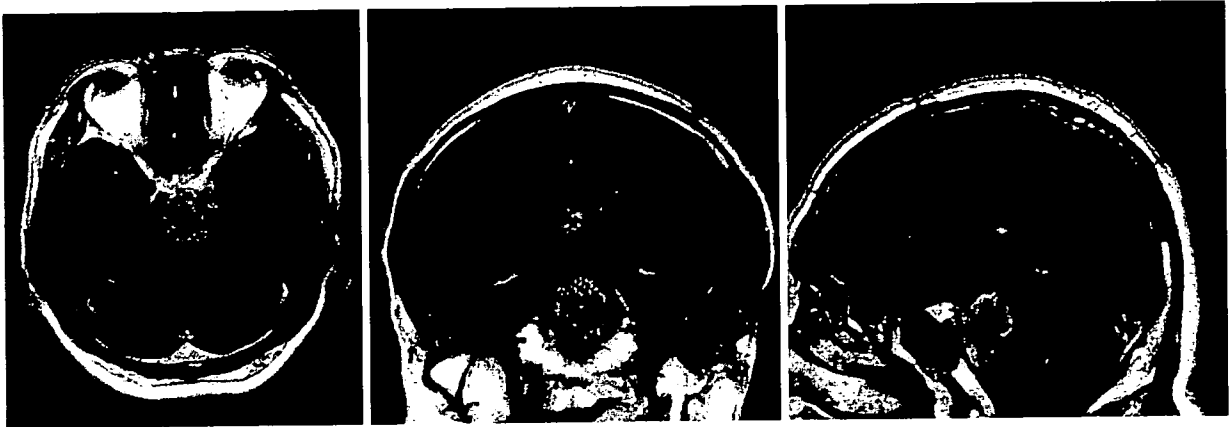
MRI (T1-Gd enhanced) 33 months after the first operation. The residual tumor is regrowing.
